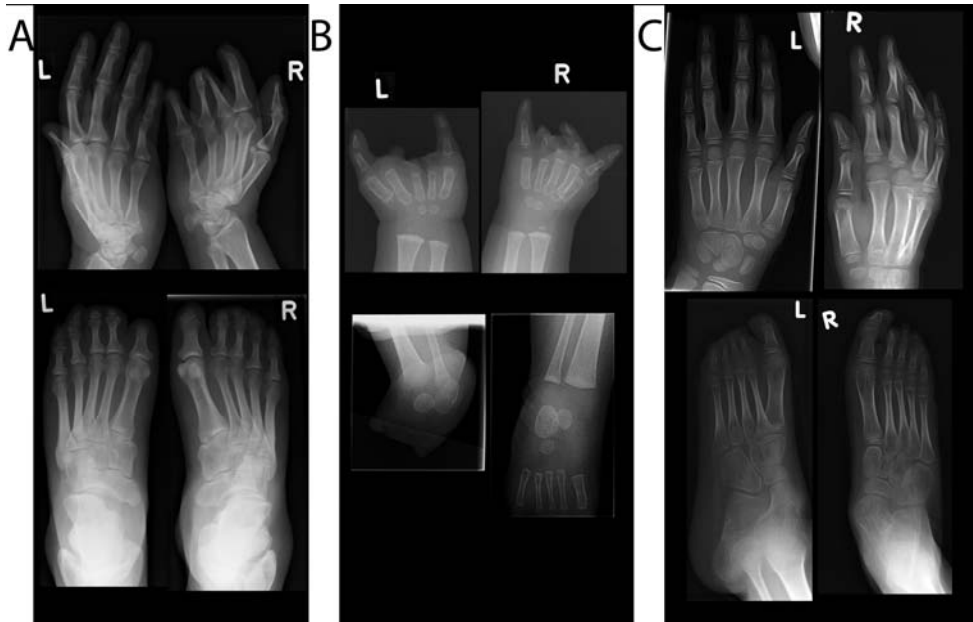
Radiographs of hands and feet. A: Patient 1 at 39 years. Upper panel: normal left hand and transverse limb deficiency of the right hand. Lower panel: feet with deficiencies on both sides. B: Patient 2 at 3.5 months. Upper panel: deficiencies of both hands. Lower panel: absence of metatarsal bones and toes of the left foot, and a normal right foot. C: Patient 3 at 9 years. Upper panel: normal hands. Lower panel: deficiencies of the left foot and a normal right foot.
